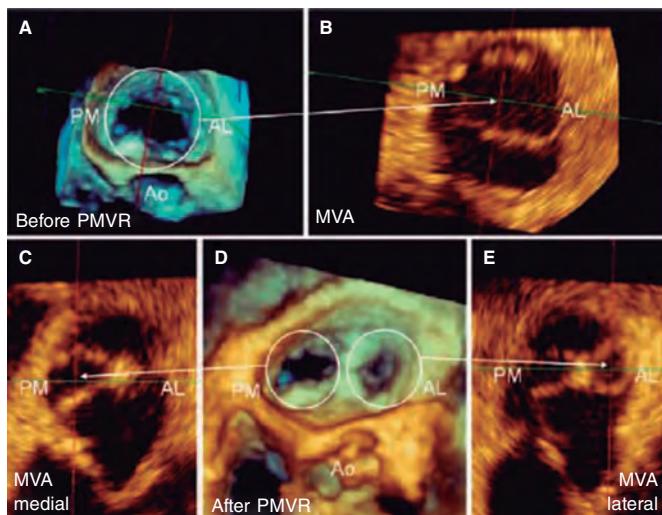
Three-dimensional transesophageal echocardiography image. A: mitral valve area (MVA) before percutaneous repair (Before PMVR) seen inside the circle. B: anterolateral (AL), and posteromedial (PM) commissure before clip implantation. The mitral valve area is shown here with an arrow. C: mitral valve area of the medial orifice (medial MVA) after clip implantation (shown by the arrow) outlined by the posteromedial (PL) commissure. D: double residual orifice after clip implantation (after PMVR); both the PM, and the AL are shown with circles. E: mitral valve area of the residual lateral orifice (lateral MVA) after clip implantation (shown by the arrow) and outlined by the AL commissure. Both residual orifices are found in different projections. Ao, aorta. Reproduced with permission from Ikenaga et al.⁵
